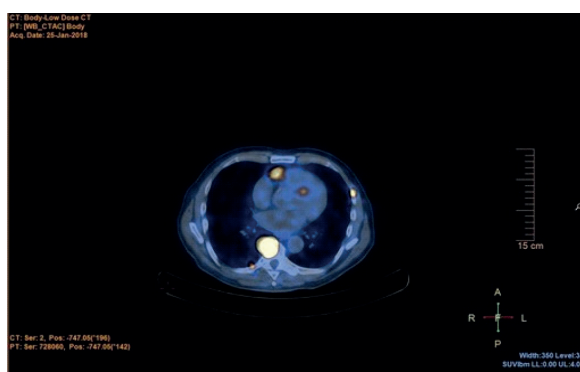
[⁶⁸Ga]-DOTATATE PET/CT before treatment with long-acting somatostatin analogues: pathological concentration of SST receptors in the area next to the pulmonary trunk, right heart ventricle and in the spine
